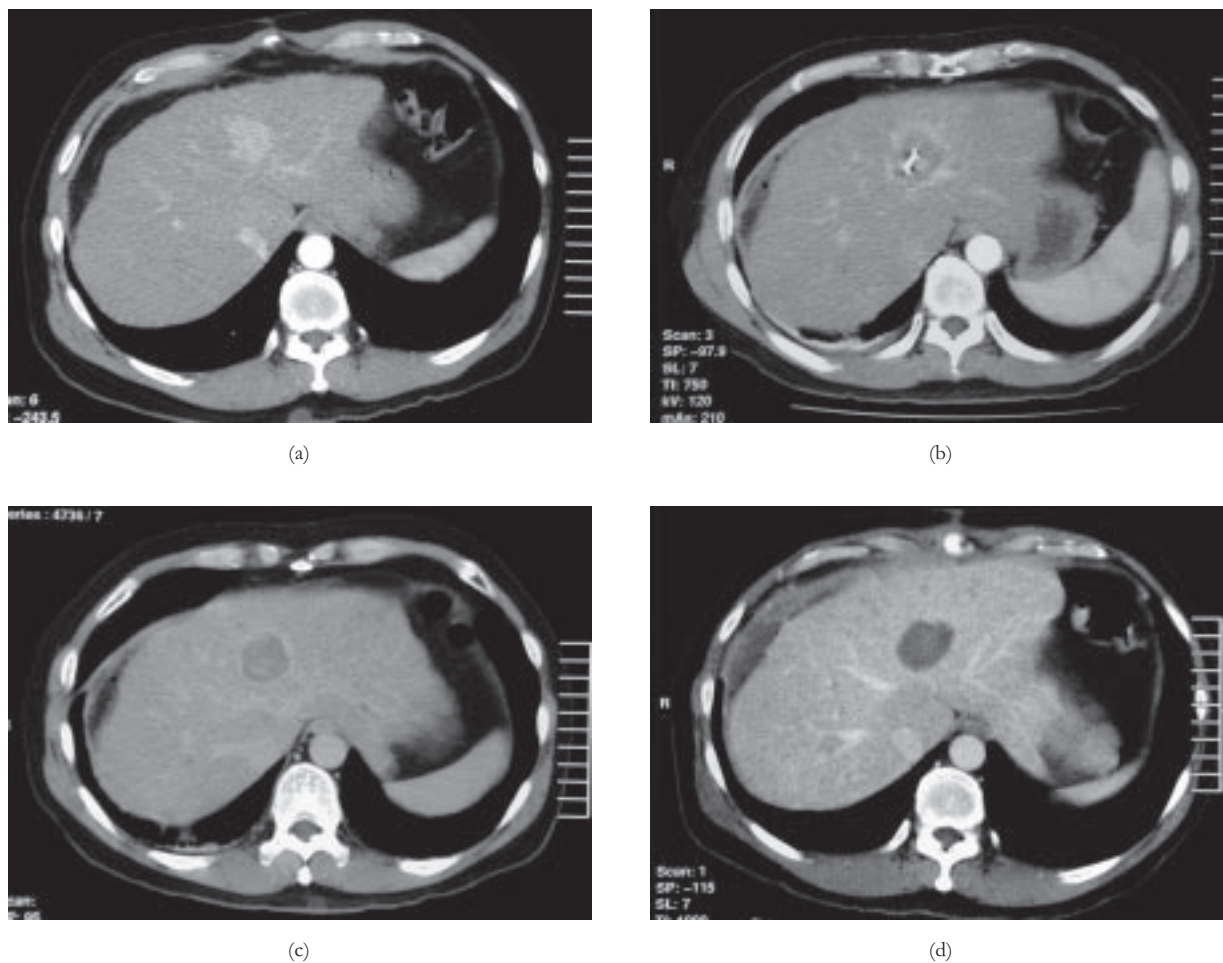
Radio-frequency ablation of hepatoma in segment 4A of the liver: changes in appearance on CT scan. Solitary and discrete hypervascular nodule in segment 4A of the liver which is consistent with hepatoma (Fig. 1a.). RF ablation of the nodule with the tip of RF needle electrode (identified by the focal hyperdensity) having been advanced into the tumour nodule using CT fluoroscopic guidance. Ablation was carried out for a duration of 12 minutes (Fig. 1b). Day 1 post-RF ablation: Tumour lesion has become hypodense with ill-defined hyperdensity within it (due to haemorrhage from the procedure) and some peri-tumoral hyperdensity as a result of reactive hyperaemia induced by the ablation procedure (Fig. 1c). One month post-RF ablation: the tumour lesion has become completely and homogeneously hypodense (equivalent to fluid density) with no evidence of peripheral nor focal enhancement to suspect residual / recurrent tumour (Fig. 1d).
